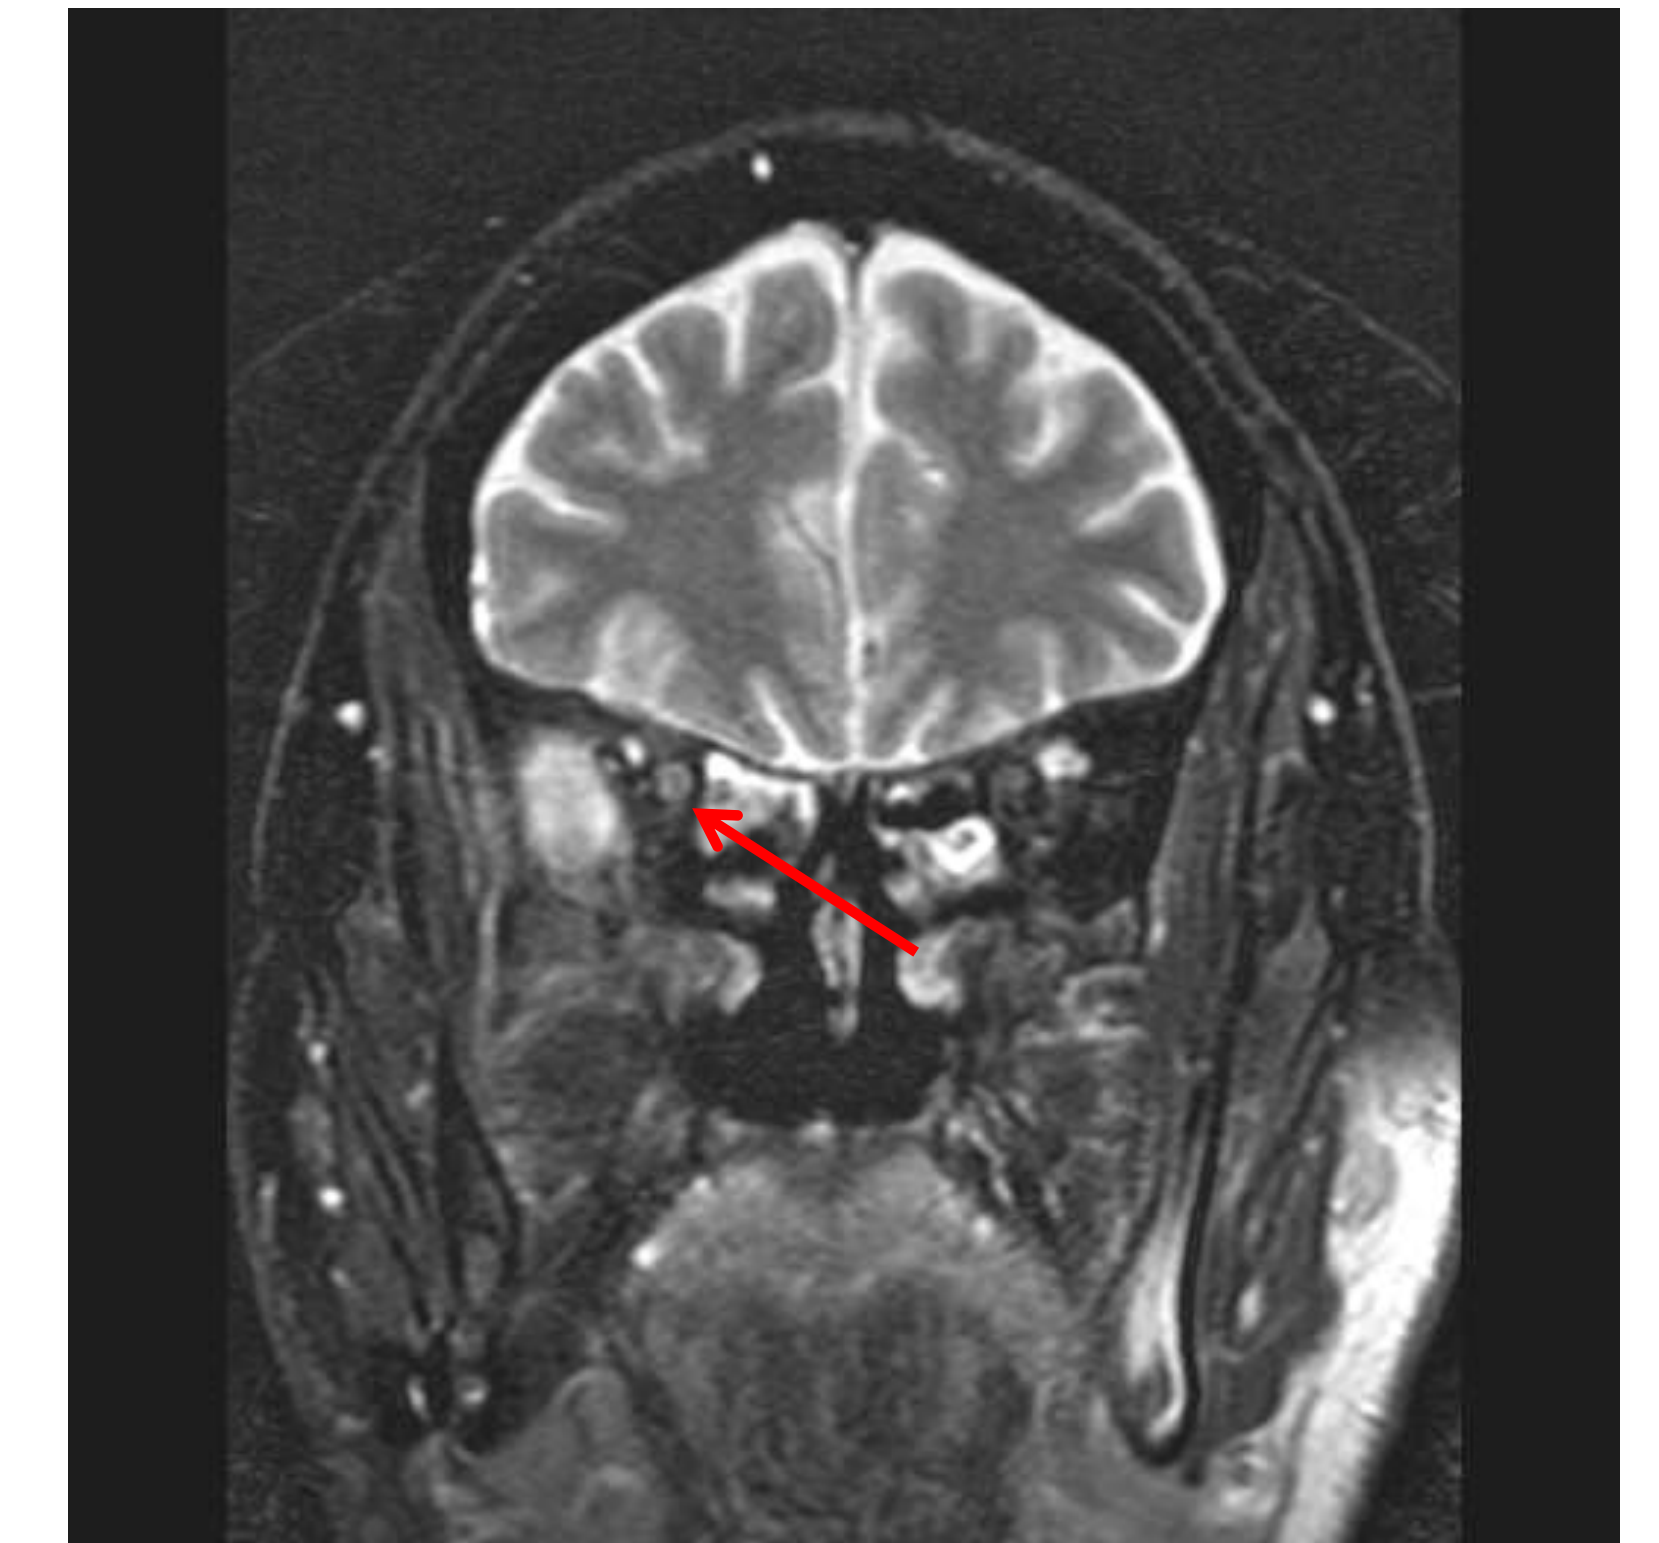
T2 post contrast MRI of the brain and orbits showing slight enhancement of the optic nerve within the optic canal (red arrow)
